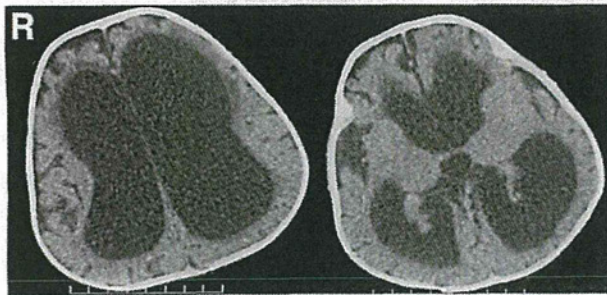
Computed tomography scans on admission showing marked ventricular dilation and periventricular lucency.
